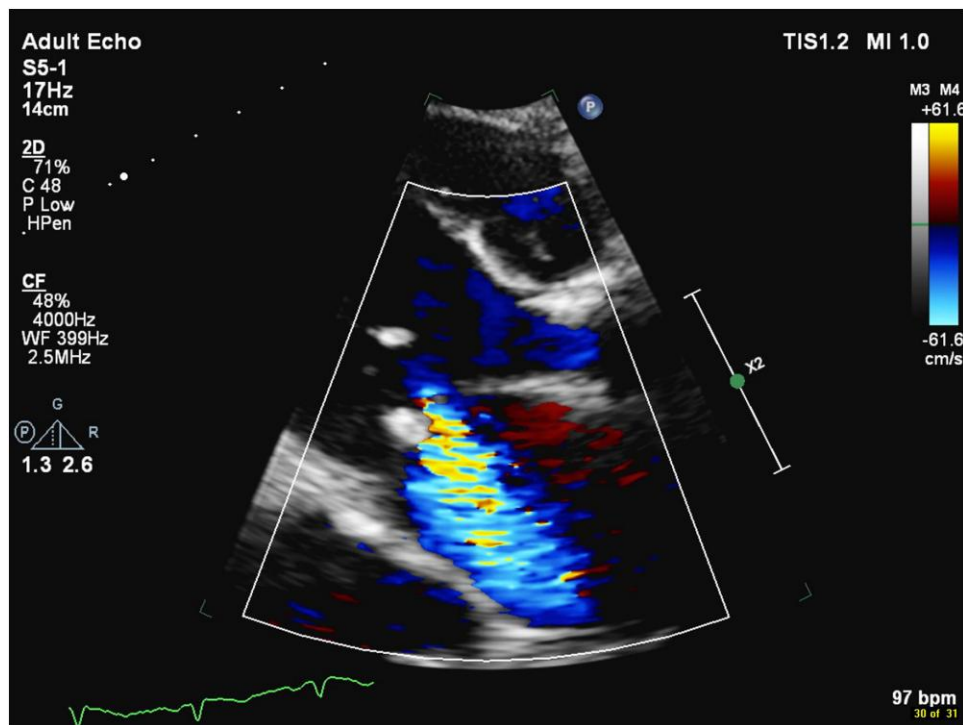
Para-sternal long-axis view with colour Doppler showing degenerative changes in the mitral valve with severe mitral regurgitation. The transcatheter aortic valve implant is seen in the aortic position.
